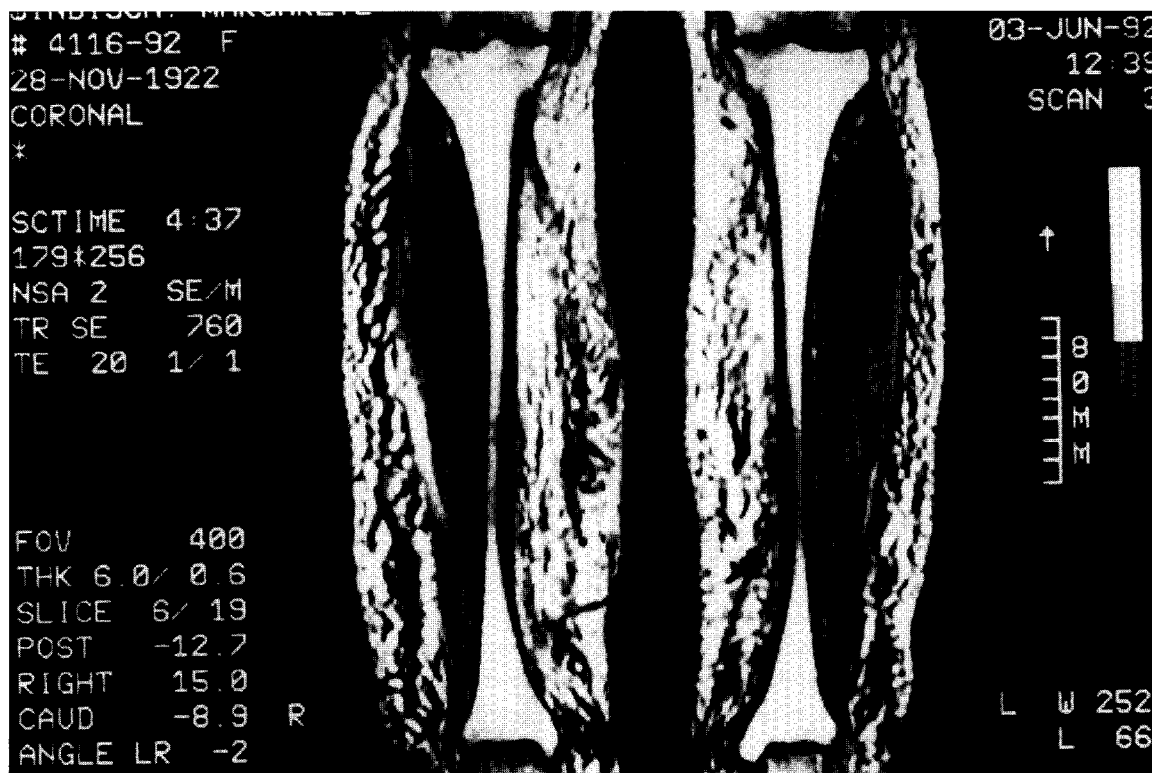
Magnetic resonance image (T2-weighted sequence) of secondary lymphedema of both legs in a 55-year old woman. Note the trabecular or honeycombed pattern in the subcutaneous tissue (compare with Fig. 2).
